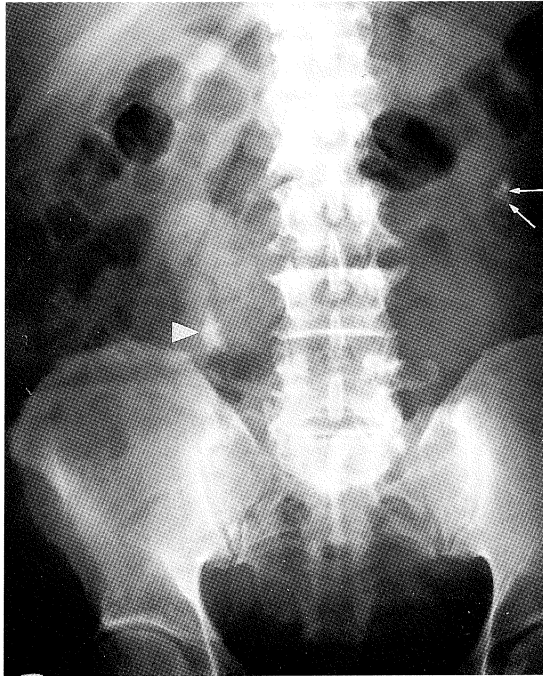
Initial abdominal radiograph shows two small left renal (small arrows) and one relatively-large right ureteric (arrowhead) calculi.
